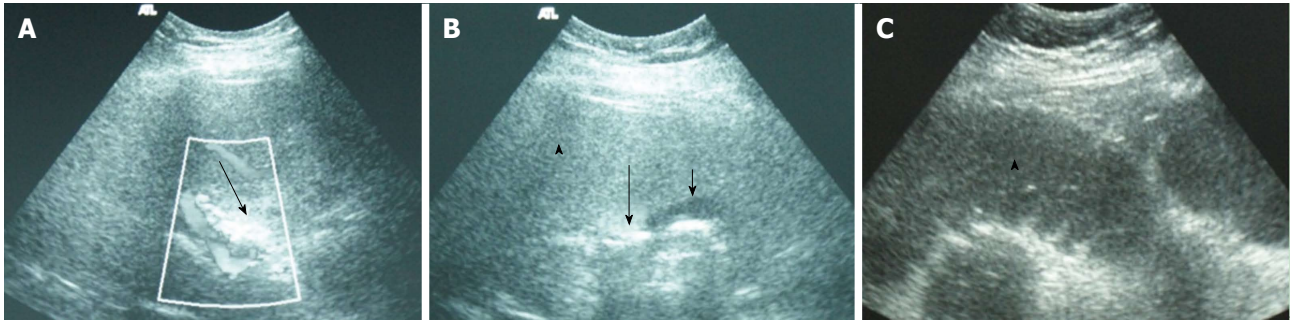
Ultrasound findings in a patient with gallstone ileus. A: Hyperechoic images without acoustic shadow in a non-dilated common bile duct, suggestive of air in the bile duct (arrow). Right portal vein was identified by Doppler US; B: US showing hyperechoic images without acoustic shadow in a collapsed gallbladder (arrow) and duodenum, suggestive of endoluminal air (short arrow). Liver parenchyma (arrowhead); C: Fluid-filled dilated proximal jejunum bowel loop (arrowhead). US: Ultrasound.
